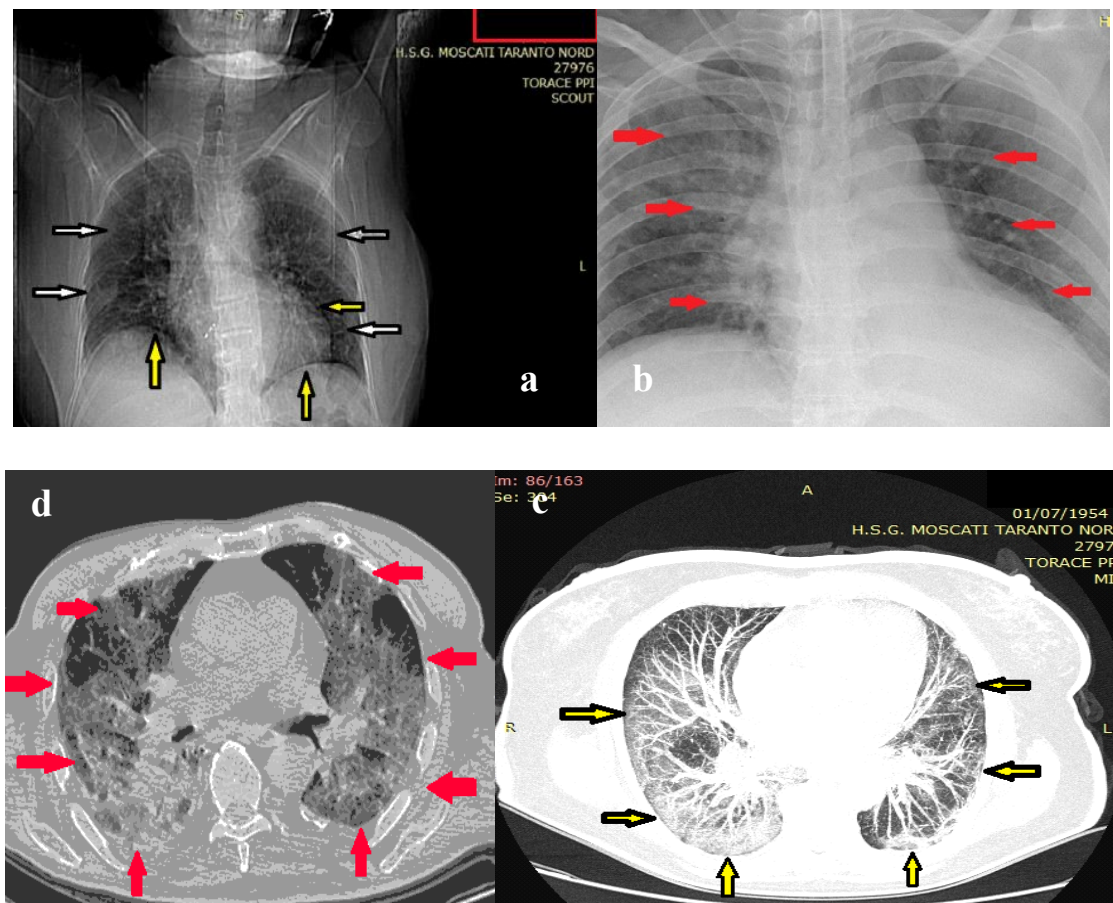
Chest CT of 38-year-old male with axial and coronal planes shows the progression of pneumonia with bilateral diffuse patchy mixed ground-glass opacities and linear opacities in the subpleural area (black/white arrow) associated with an anterior pericardial effusion (yellow arrows) (a-b); bilateral diffusely ground-glass opacity (yellow arrows) from a 66-year-old man with predominant cardiomegaly (red arrows) (c-d).
